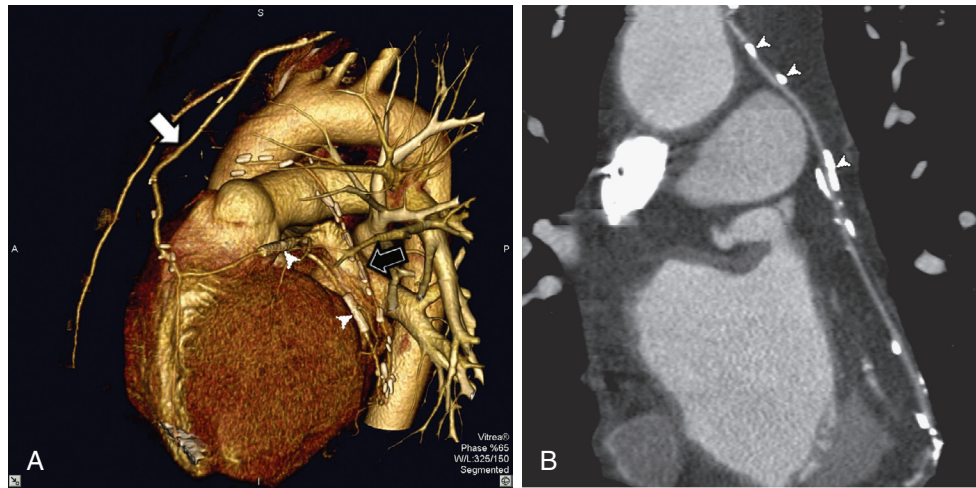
■ A, A three-dimensional volume-rendered cardiovascular computed tomographic image of a left internal mammary graft to the left anterior descending coronary artery (white arrow) and a reverse saphenous vein graft to an obtuse marginal graft (black arrow). Note the stents in the native coronary vessels (arrowheads). B, Curved multiplanar cardiovascular computed tomographic image of the left internal mammary graft to the left anterior descending coronary artery in the same patient, demonstrating multiple surgical clips (arrowheads).
